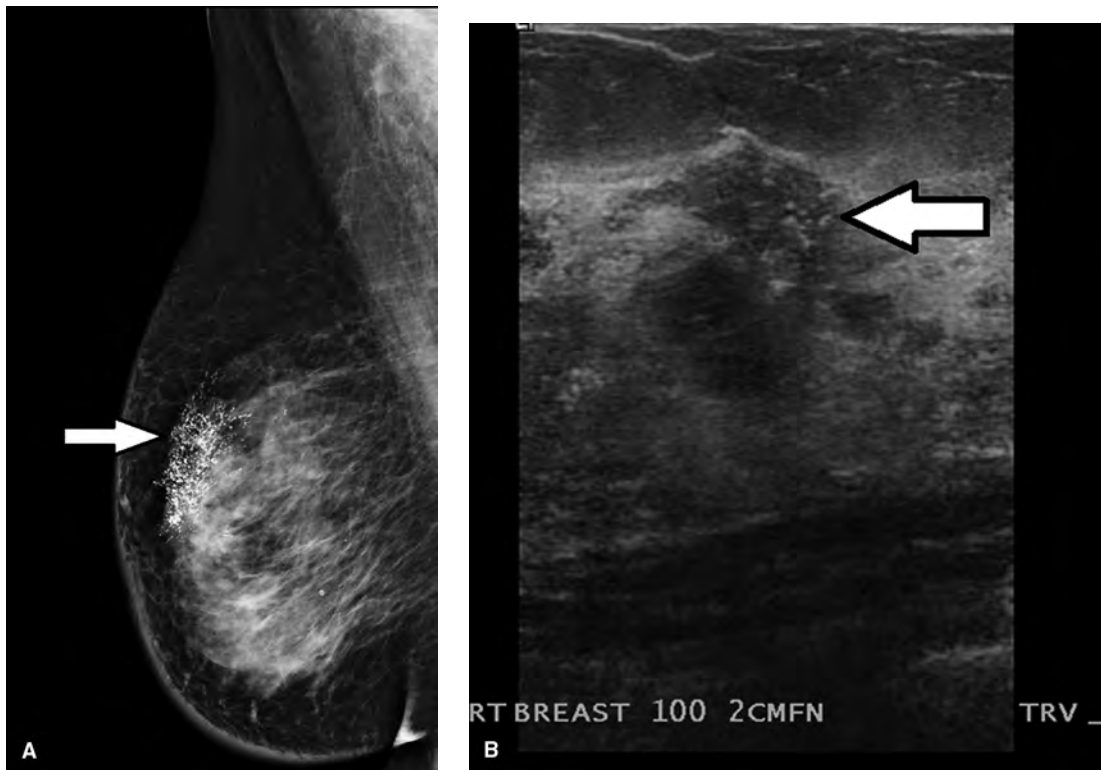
(A) Pleomorphic calcifications on mammography in upper inner right breast without associated mammographic mass (*arrow*). (B) Irregular corresponding mass on sonography. Note calcifications (*arrow*).
